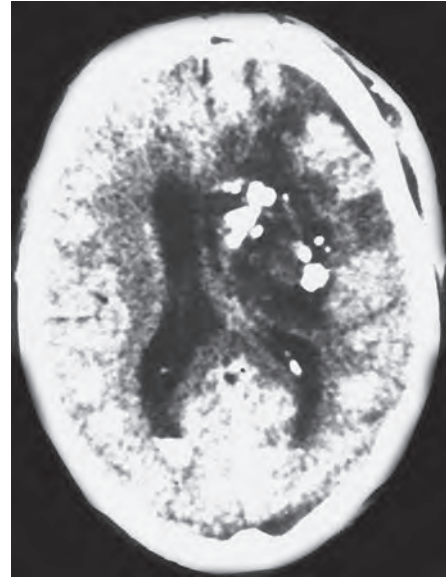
CT brain showing intracerebral splinter, oedema and intraventricular haemorrhage
